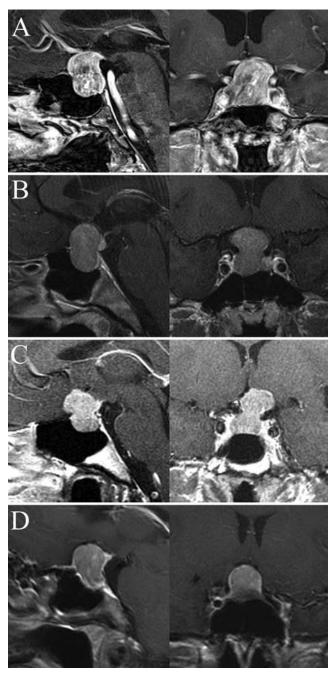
A–D: Sagittal and coronal contrast-enhanced MR images of typical NFMAs demonstrating suprasellar extension. A characteristic "dumbbell" or "sand-glass" shape with constriction, or a "waist," at the diaphragma sellae is noted in panels B and C.
